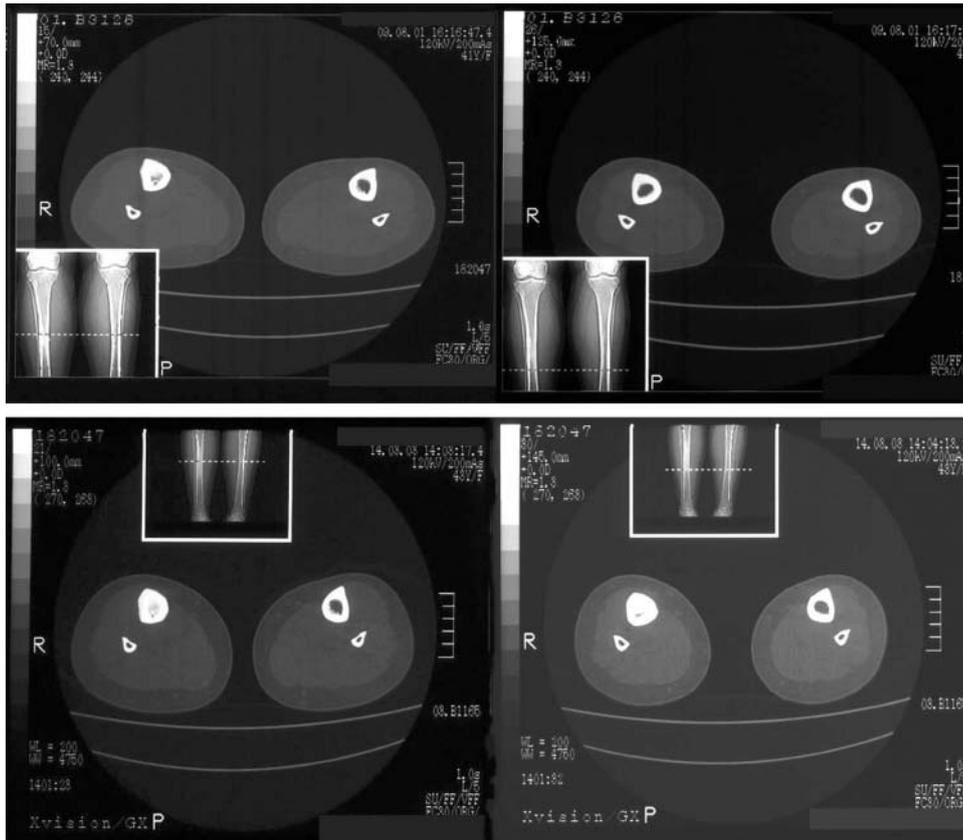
Transaxial CT images showing cortical thickening and a sclerosing lesion in the medullary region of the right tibia.
